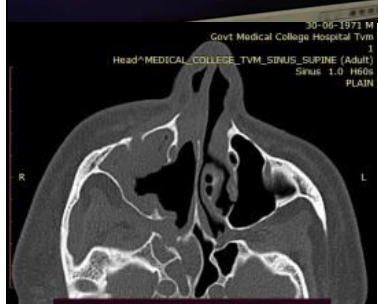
Axial non contrast CT reveals destructive sinonasal soft tissue mass
